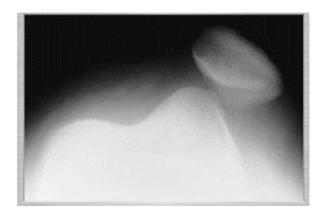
Lateral dislocation of the patella (radiograph from the author's collection)
